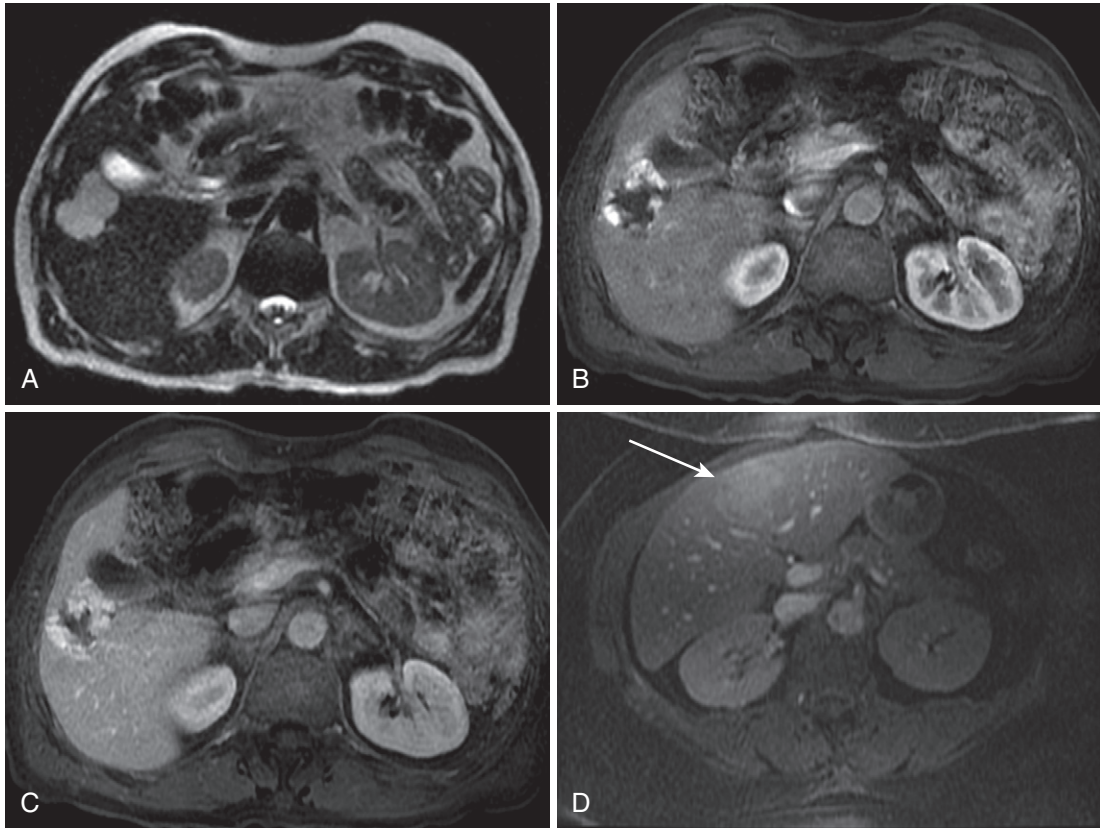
Hemangioma. A, The hemangioma with a characteristic lobulated border demonstrates moderately high hyperintensity on the heavily T2-weighted image (A), but less than the adjacent fluid-filled gallbladder. The arterial phase image (B) demonstrates the typical clumped, discontinuous peripheral enhancement, which gradually progresses centripetally to complete uniform hyperintensity, as seen (*arrow* in D) on the portal phase (C) and delayed (D) images in a different patient.
